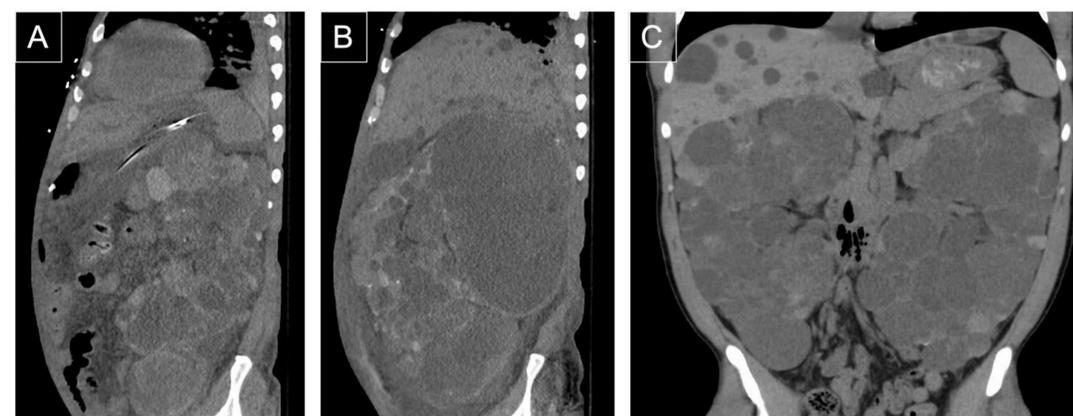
Preoperative CT images of polycystic kidneys: (A) largest right kidney removed 29.3 cm craniocaudally; (B) largest left kidney removed 31.8 cm craniocaudally; (C) bilateral kidneys cross midline and nearly fill the abdominal cavity.
